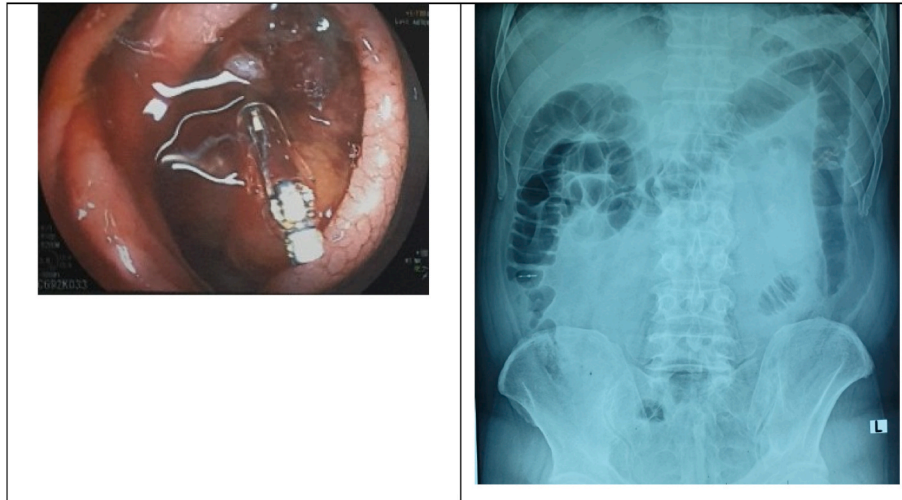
Using additionally metal clips next to the tumor, an abdominal X-ray film was performed could show the location of the tumor on the colonic frame
